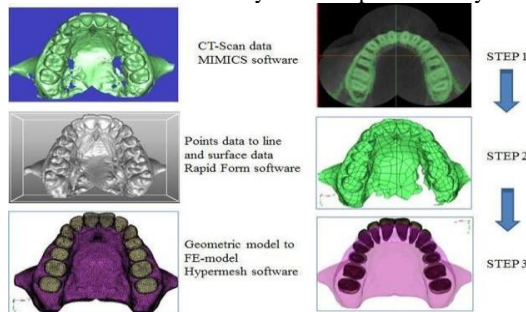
Summary of sequence of conversion process from the stage of CBCT scan
